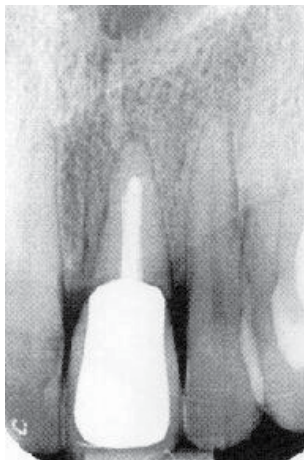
Single X-ray at the beginning of treatment.
